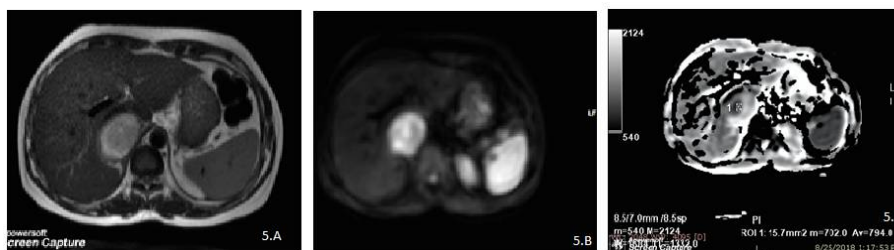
A, B: A case diagnosed as malignant neoplasm of head of pancreas showing areas of diffusion restriction on DWI sequence (A) and corresponding areas of ADC reversal (B).
